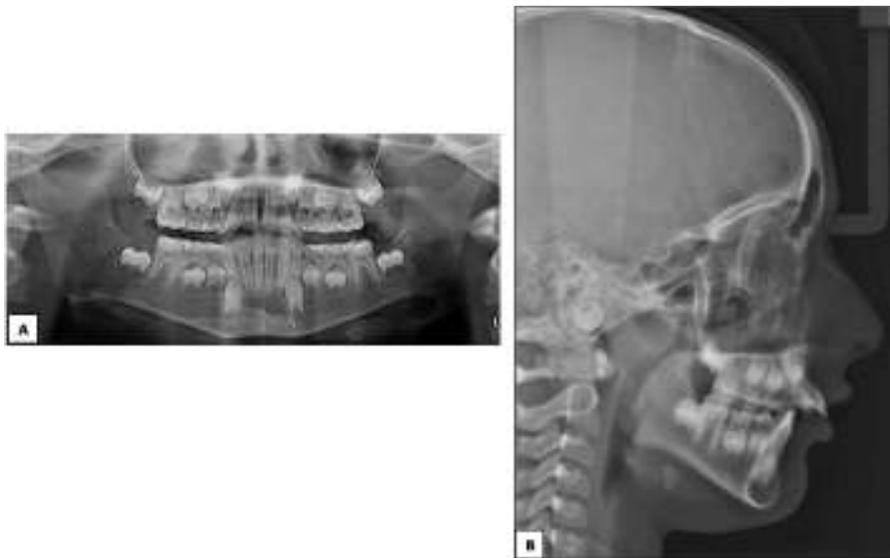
Pre-functional: (A) Panoramic radiograph and (B) Lateral cephalogram
